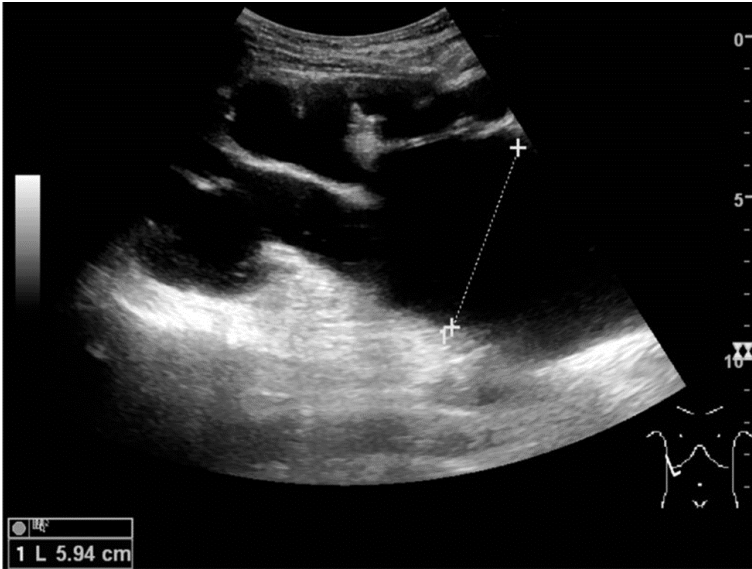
Ultrasonography of end-stage hydronephrosis. [End-stage hydronephrosis with cortical thinning](#) by Hansen KL, Nielsen MB, Ewertsen C licensed under [CC BY 4.0](#)
